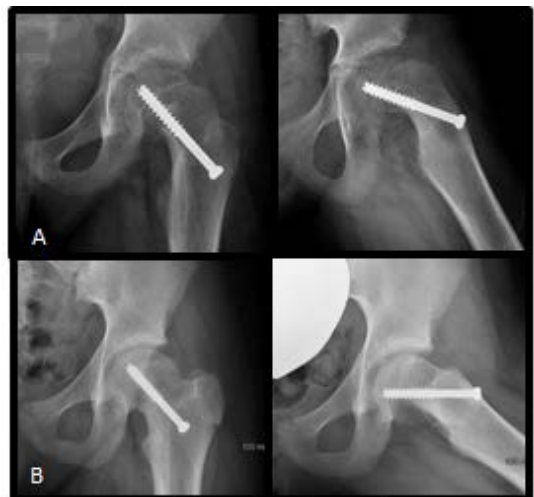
AP and lateral radiographs post-op (A) and 2-years (B) after screw fixation of SCFE
